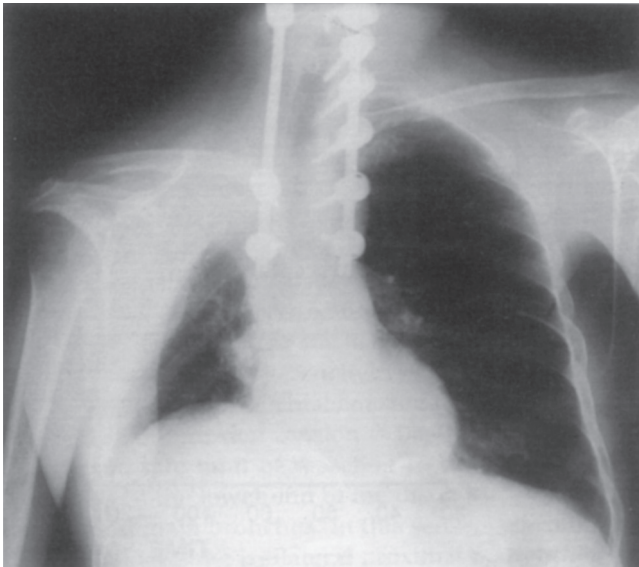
■ Chest radiograph showing bilateral spinal fixation with metal rods interposed. (From Darteville PG: Extended operations for lung cancer. *Ann Thorac Surg* 63:12, 1997, with permission.)
